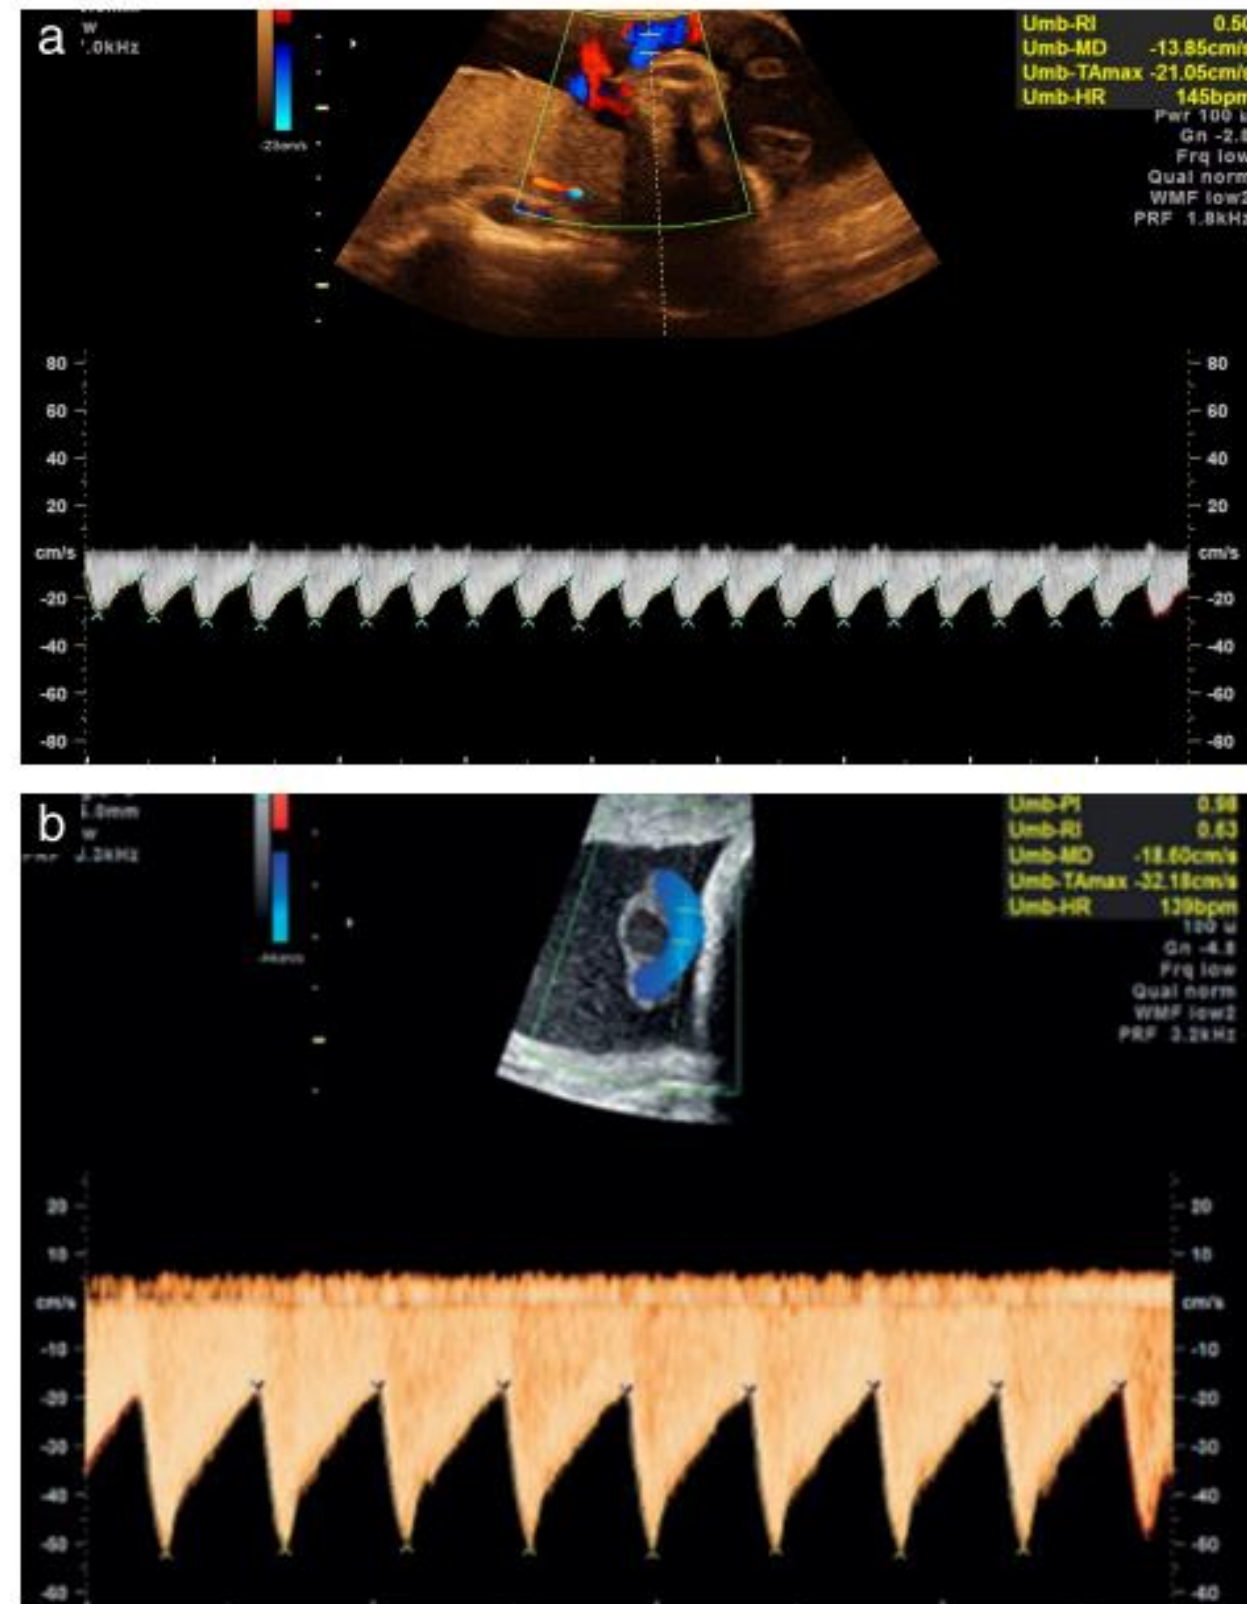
Examples of unacceptable (a) and acceptable (b) umbilical artery waveforms. The recording is improved by reducing the Doppler scale (i.e. reducing the pulse repetition frequency) to magnify the velocity recording on the screen, as well as adjusting the sweep speed to cover only three to nine consecutive waves.
